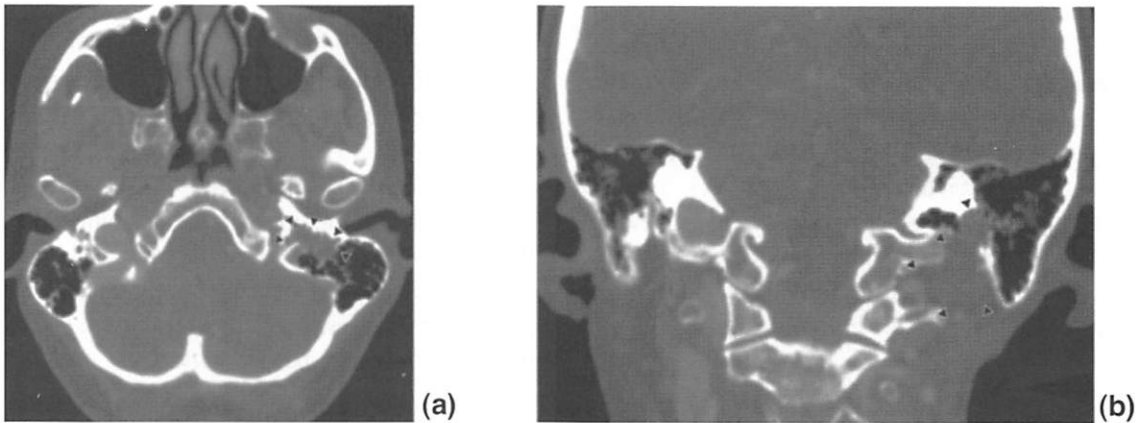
Computed tomography (CT) shows tumor extending into the temporal bone along the route of the facial nerve from stylomastoid foramen (arrow heads, a; axial, b; coronal).
